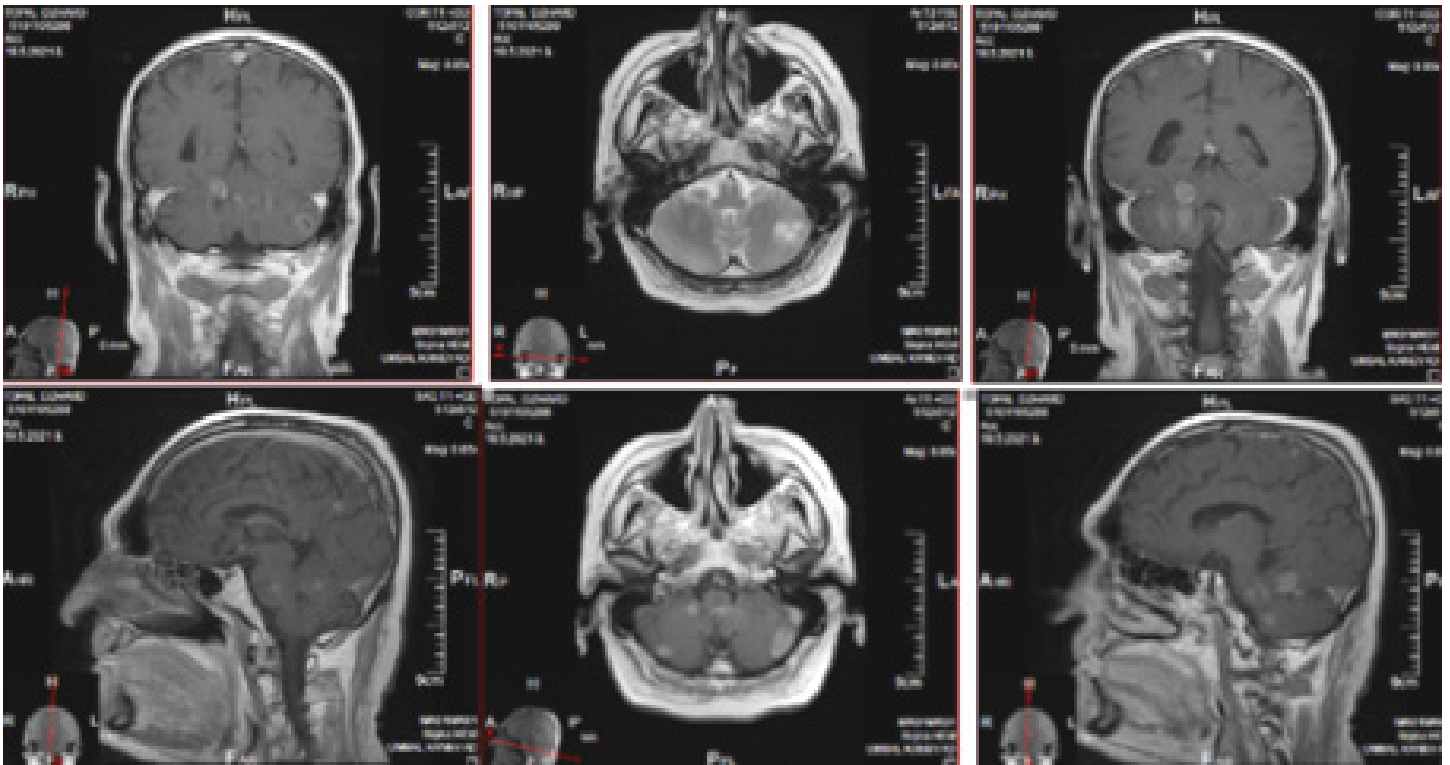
COR T1 FLAIR MRI; SAG T1 FLAIR MRI; AX T1 FLAIR MRI 2 months after radiosurgery - multiple sub- and supratentorial leptomeningeal metastases.
